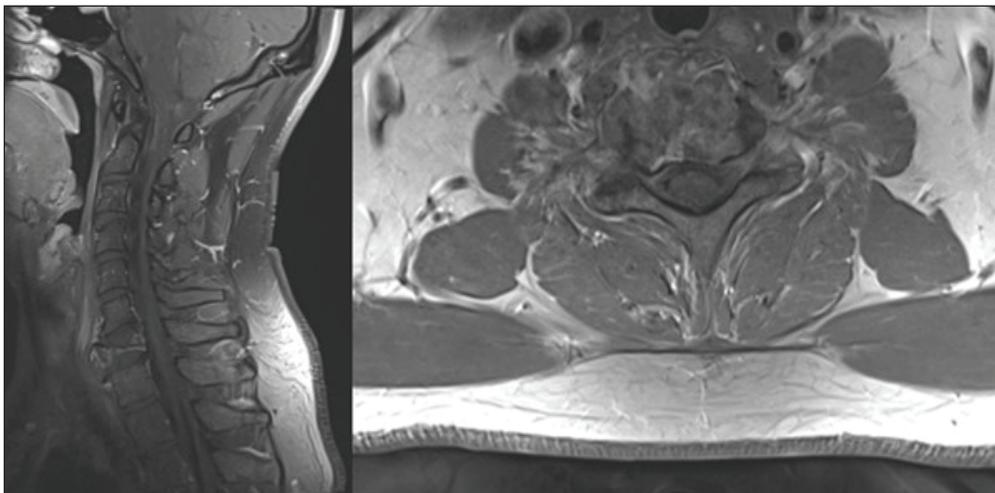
Preoperative T1 enhanced sagittal and axial MRI views in patient 1.
